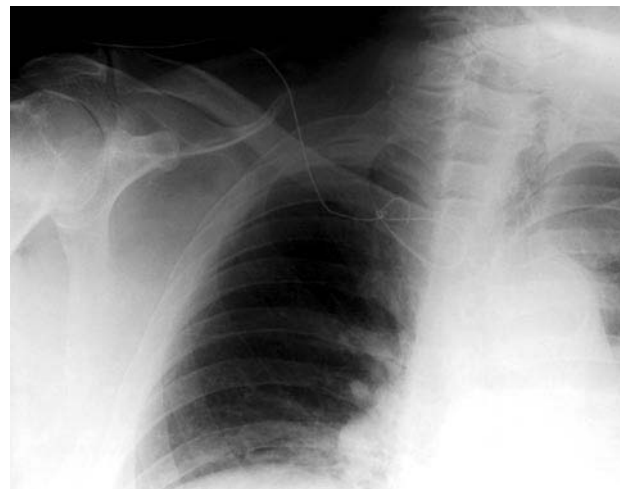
Chest radiograph of the patient showing a knotted guidewire in the subclavian vein.
